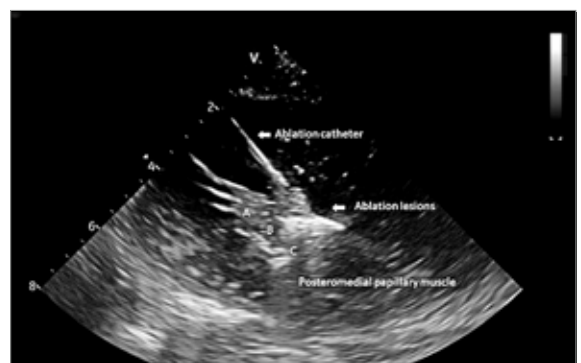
The ablation catheter on top of the body of the papillary muscle is shown. Intracardiac echocardiography (ICE) confirms adequate catheter-tissue contact during the procedure. Local lesion formation was monitored on ICE through changes such as tissue swelling resulting in increased echo density. A: Tip, B: Body, C: Base.
